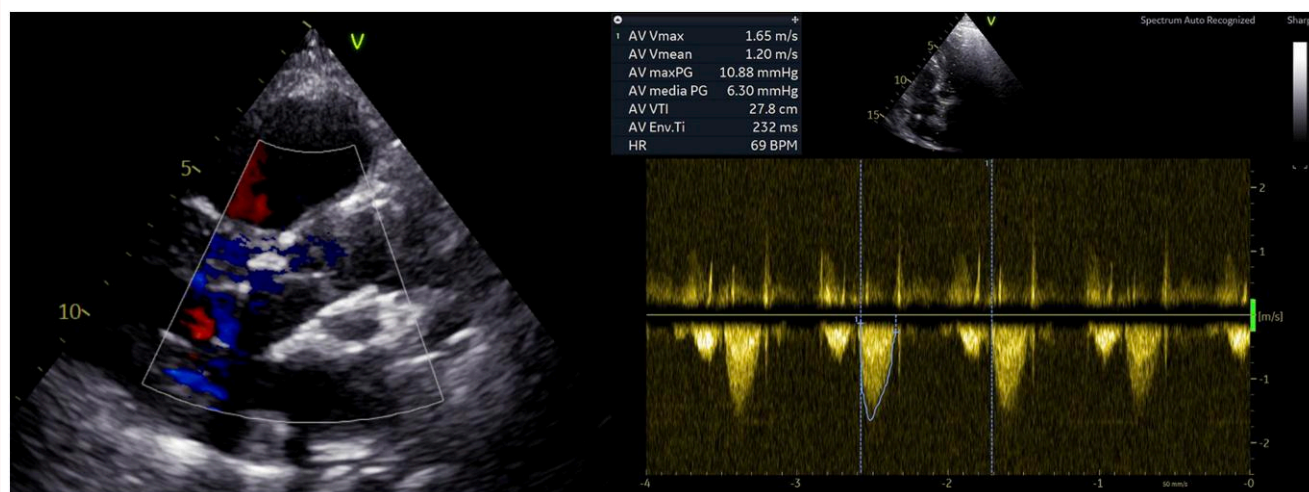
(A, B) Post-procedural transthoracic echocardiography with residual gradient of 4 mmHg without significant leak. (C) Transthoracic echocardiography at 6-month follow-up showing no substantial increase in transvalvular gradient (V_{\max} 1.65 m/s, mean gradient 6 mmHg).
